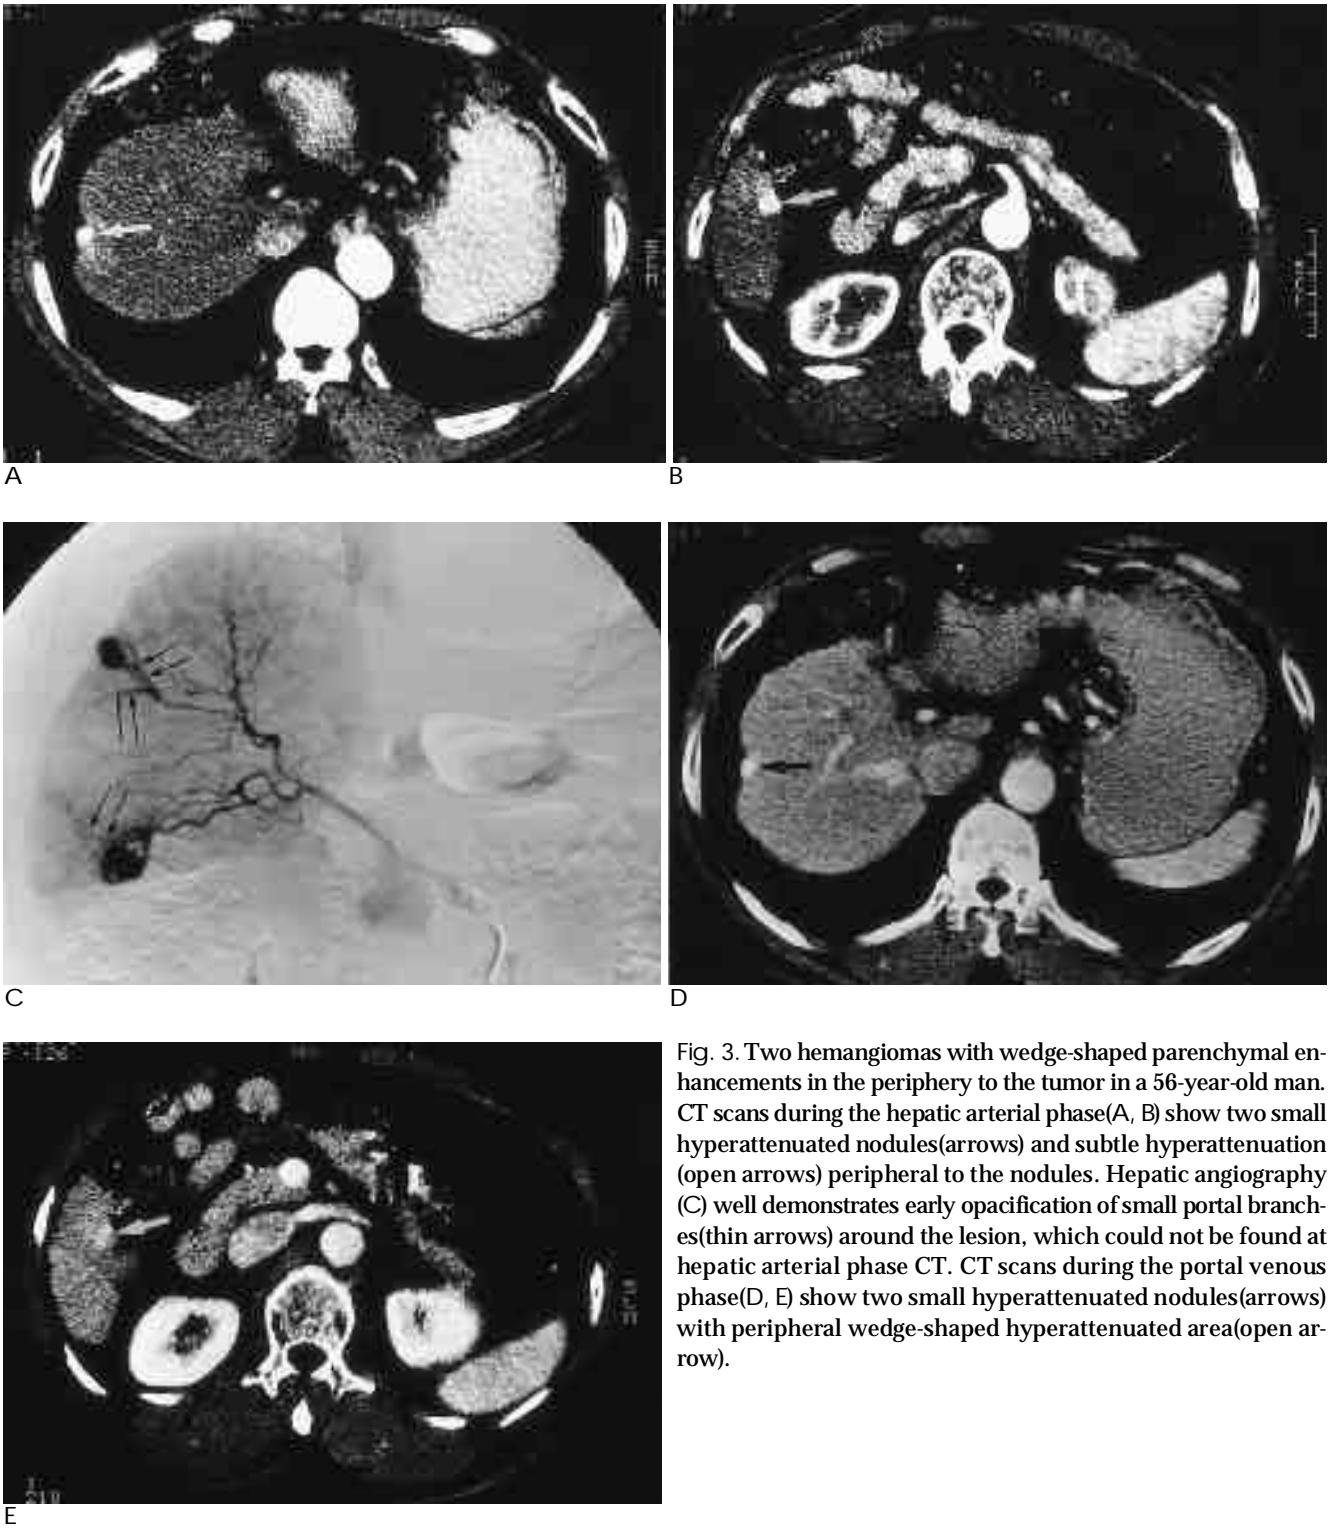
Two hemangiomas with wedge-shaped parenchymal enhancements in the periphery to the tumor in a 56-year-old man. CT scans during the hepatic arterial phase(A, B) show two small hyperattenuated nodules(arrows) and subtle hyperattenuation (open arrows) peripheral to the nodules. Hepatic angiography (C) well demonstrates early opacification of small portal branches(thin arrows) around the lesion, which could not be found at hepatic arterial phase CT. CT scans during the portal venous phase(D, E) show two small hyperattenuated nodules(arrows) with peripheral wedge-shaped hyperattenuated area(open arrow).
